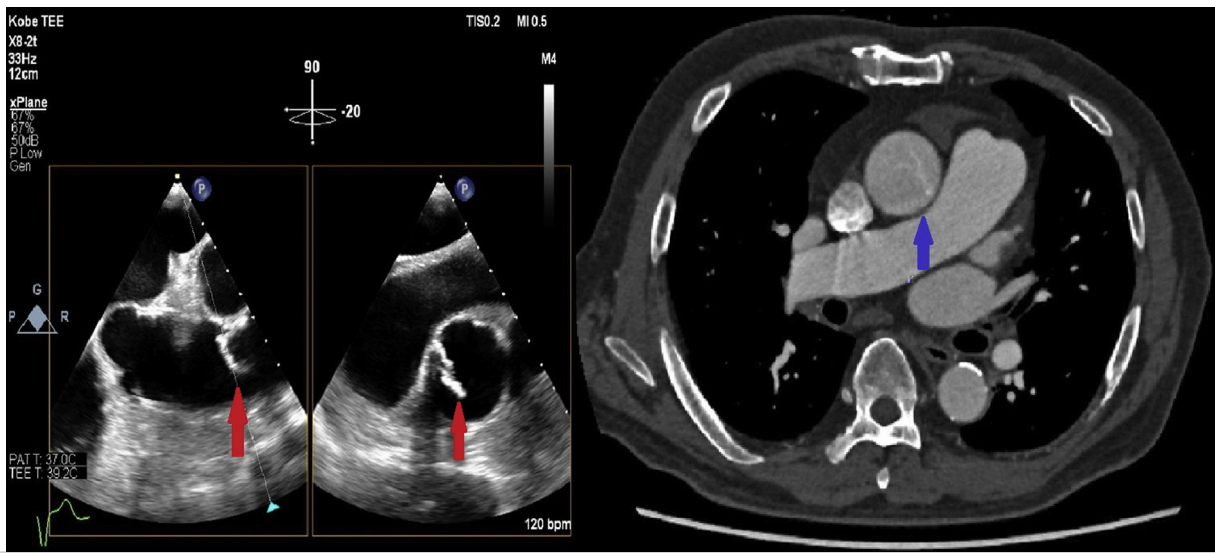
Transesophageal echocardiography shows the mobile mass with acoustic shadow in the ascending aorta (red arrow). This mass is swinging periodically with the heartbeat of the man. Computed tomography (CT) reveals the highly enhanced mass in the ascending aorta (blue arrow).
